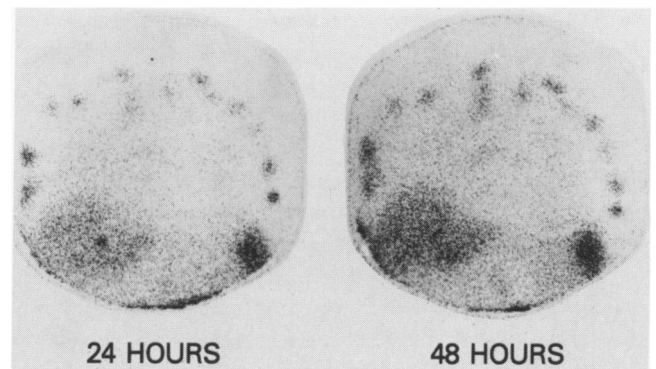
Serial scans in a patient imaged with <sup>111</sup>In-9.2.27 monoclonal antibody injected subcutaneously. Excellent delineation of epitrochlear, axillary, cervical, and mediastinal nodes is noted. A small persistent hot spot in the mid portion of the liver had no radiologic (CT scan) or ultrasound correlate, and recent repeat studies at 1 year demonstrate no apparent disease in that organ.
